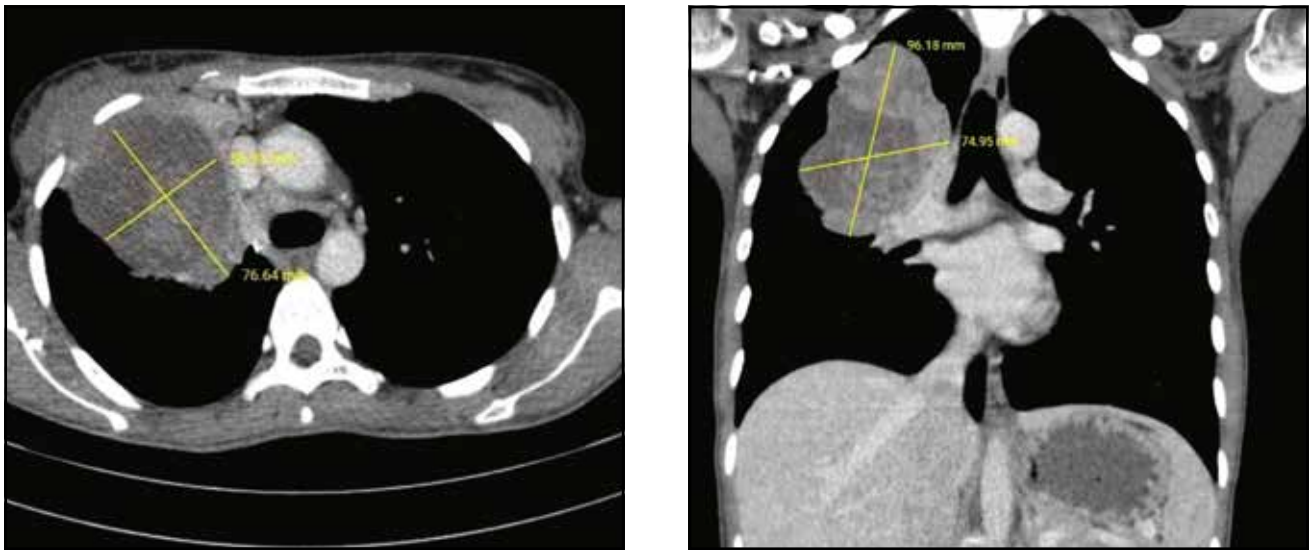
CT scan of the thorax and abdomen (axial and coronal slices): multiple mediastinal lymph nodes and a voluminous lung formation in the right superior pulmonary lobe, with an irregular contour (axial slice and coronal slices); 2 cystic-like hepatic lesions developed in segments IV and VIII (coronal slice).
